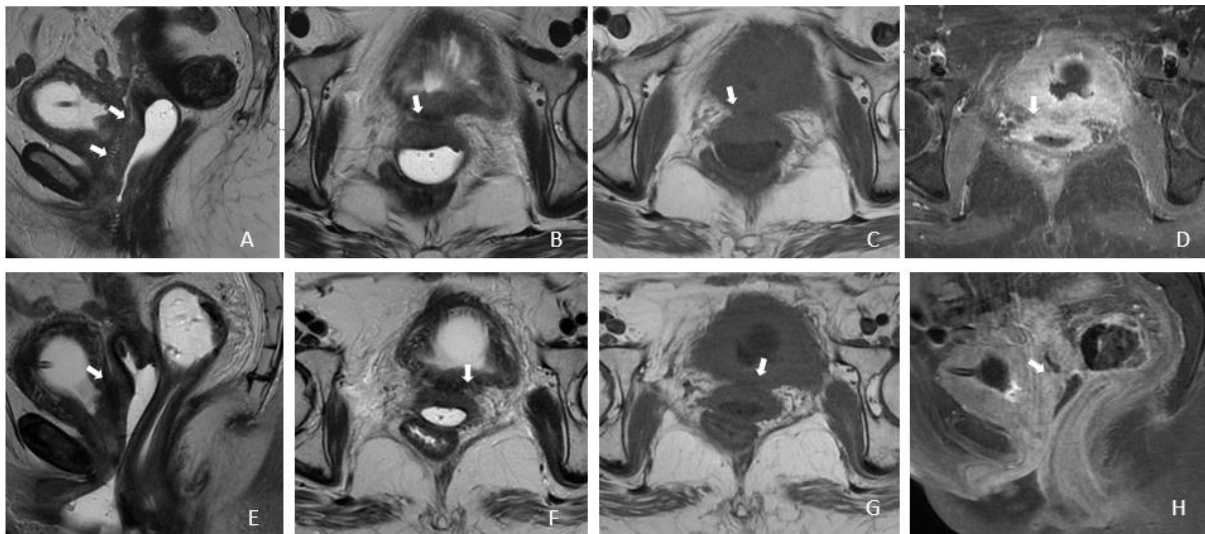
First MRI:(A) Sagittal T2-weighted MR image, (B) Axial T2-weighted MR image, (C) Axial T1-weighted MR image, (D) Axial T1-weighted FS postcontrast MR image shows a hypo-intensity on T1 and T2, and early enhancement of the hemi circumferential thickening measuring 13,6 x 37mm arising from the anterior wall of the upper vagina. Invading the bladder neck and paravaginal fat (arrow).
